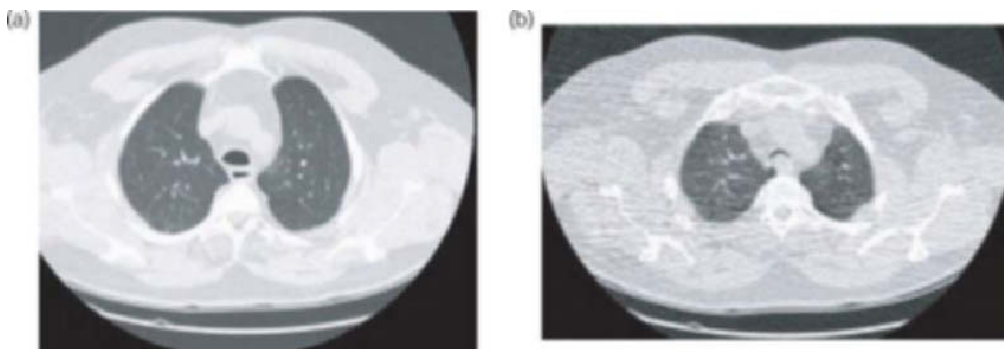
Two-dimensional CT airway reconstruction of the trachea. (a) Depicts the trachea in inhalation; (b) demonstrates tracheal collapse in exhalation.
